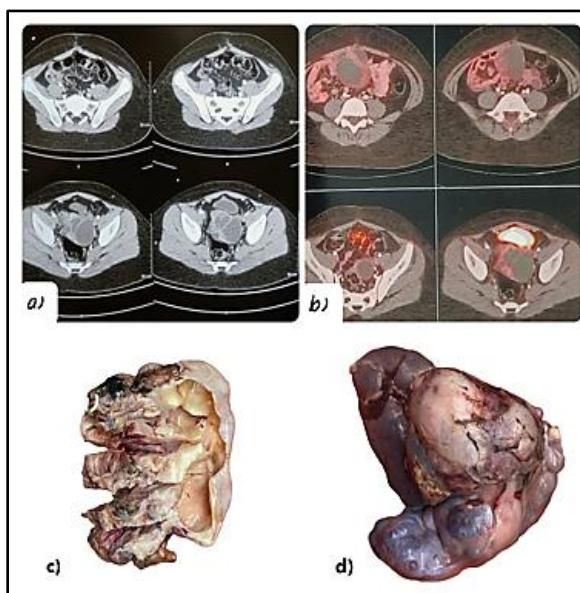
a) Multiple pelvic deposits in CT scan, b) Multiple non FDG avid pelvic deposits and FDG avid lesion adherent to uterus in PETCT scan, c) Gross image of deposit in peritoneum, d) Gross image of solid-cystic lesion in spleen.
